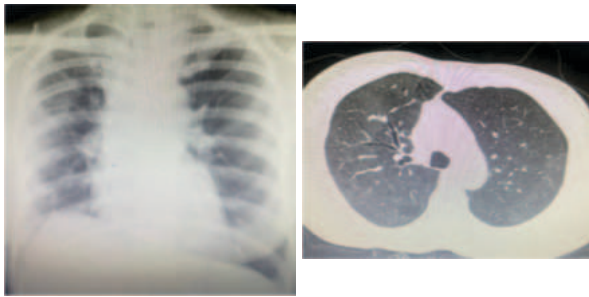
Frontal chest radiograph obtained after one month of corticosteroid therapy demonstrates near-complete resolution of pulmonary opacities.
